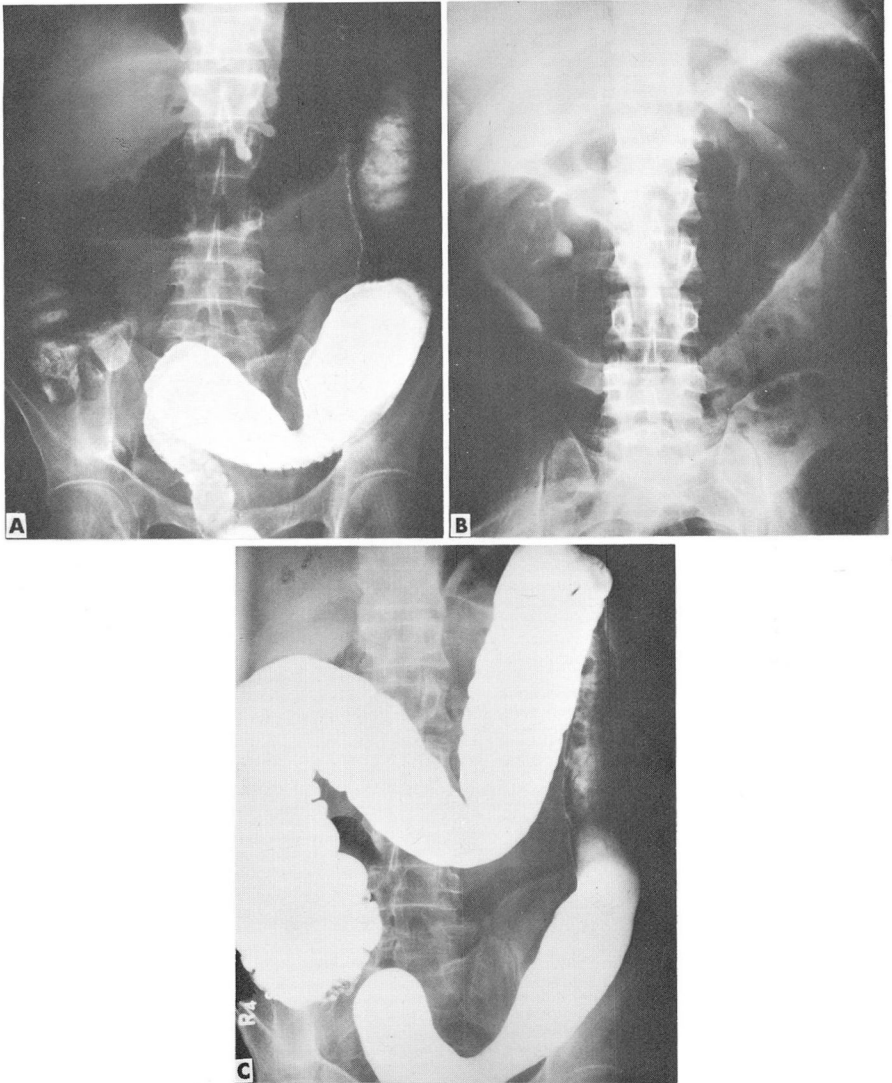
A, Roentgenogram taken on September 7, 1963, showing evidence of acute ulcerative colitis. Note ulcerations throughout the colon. B, Roentgenogram taken on September 13, 1963, showing toxic megacolon. C, Roentgenogram taken on April 12, 1965, after nitrogen mustard therapy, showing no evidence of ulcerative activity.
